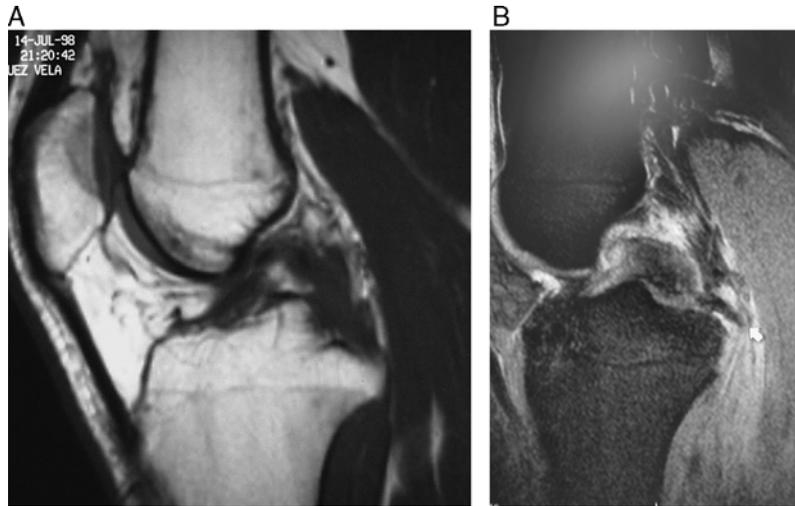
A, Sagittal MRI image of femoral-sided PCL injury. B, Sagittal MRI showing tibial-sided PCL avulsion injury. MRI indicates magnetic resonance imaging; PCL, posterior cruciate ligament.
